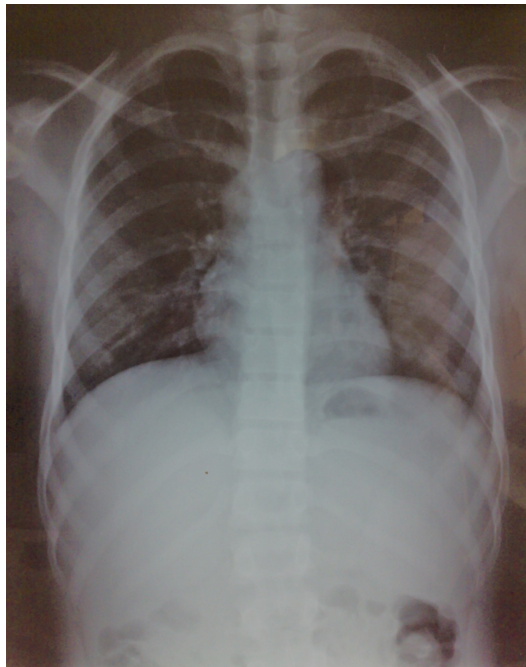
Plain X-ray, anteroposterior view of the chest, as part of the skeletal survey, shows no involvement of the ribs.
